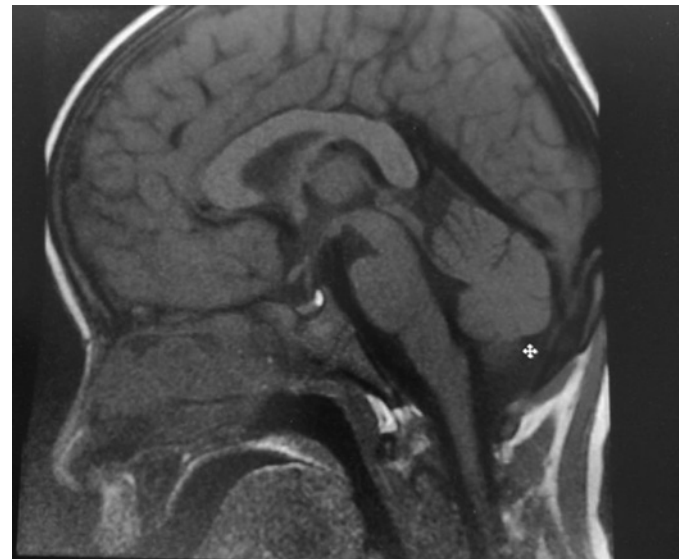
MRI brain-sagittal T1-weighted images showing the reduced pituitary height for age of 3 mm with a normal posterior pituitary bright spot. The stalk appears normal. Rest of the brain parenchyma reported to be normal.
